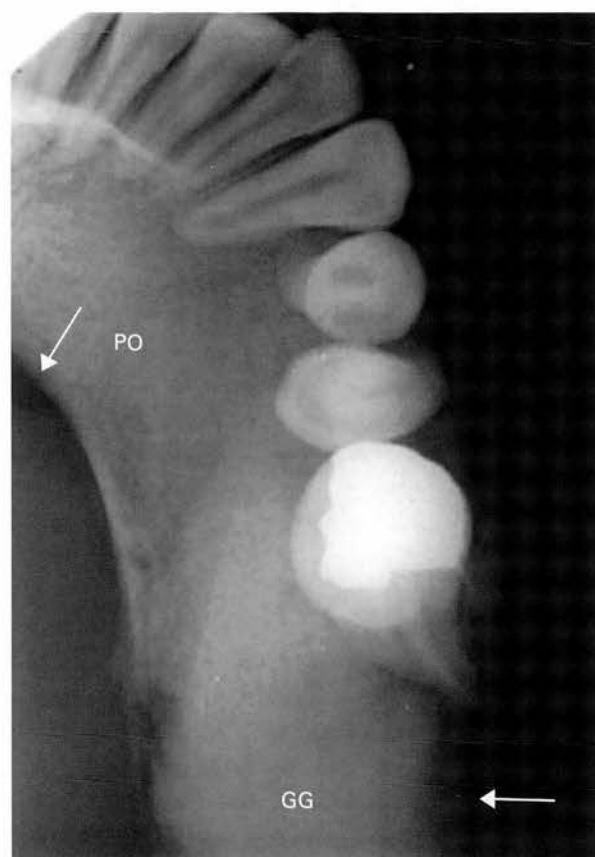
(Case 2) A true occlusal radiograph displays the variety of density and pattern seen in fibrous dysplasia, 'ground glass' (GG) posteriorly and 'peau d'orange' (PO) anteriorly. The cortex has been expanded and substantially thinned (arrows) not only posteriorly where the subjacent dysplastic tissue is more translucent, but also medially anteriorly. The roots of the premolars and first molar have been displaced buccally
